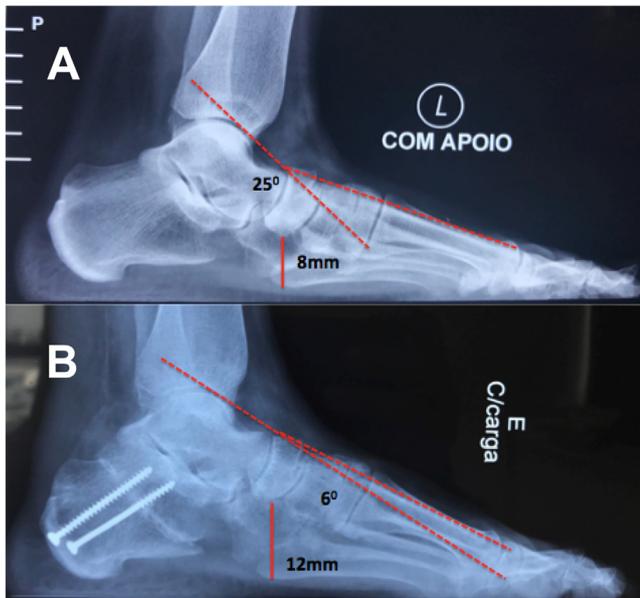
A) Pre- and B) postoperative lateral radiographs of a foot treated by FDL transfer, calcaneal osteotomy, and peroneus brevis to longus tenodesis. Observe the talus-first metatarsal angle correction from 26° to 6° and improvement in navicular-fifth metatarsal distance from 8 to 12 mm.
